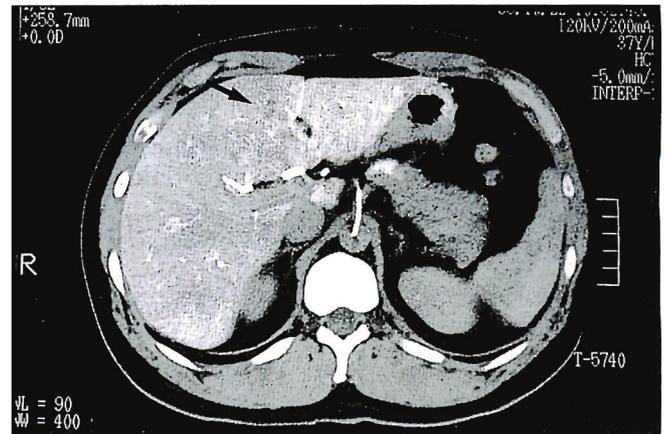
CT angiography findings were identical to the dynamic CT findings (Case 1).
